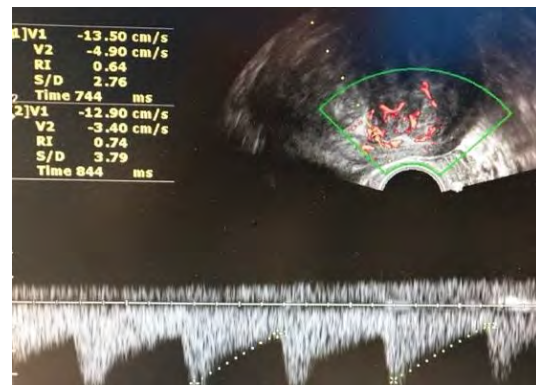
LM: Normal peripheral vasculature at Doppler sometimes the Resistance index (RI) can help out. Normal curves and RI of the vessels 0.74 (cut off for malignancy RI 0.45)
